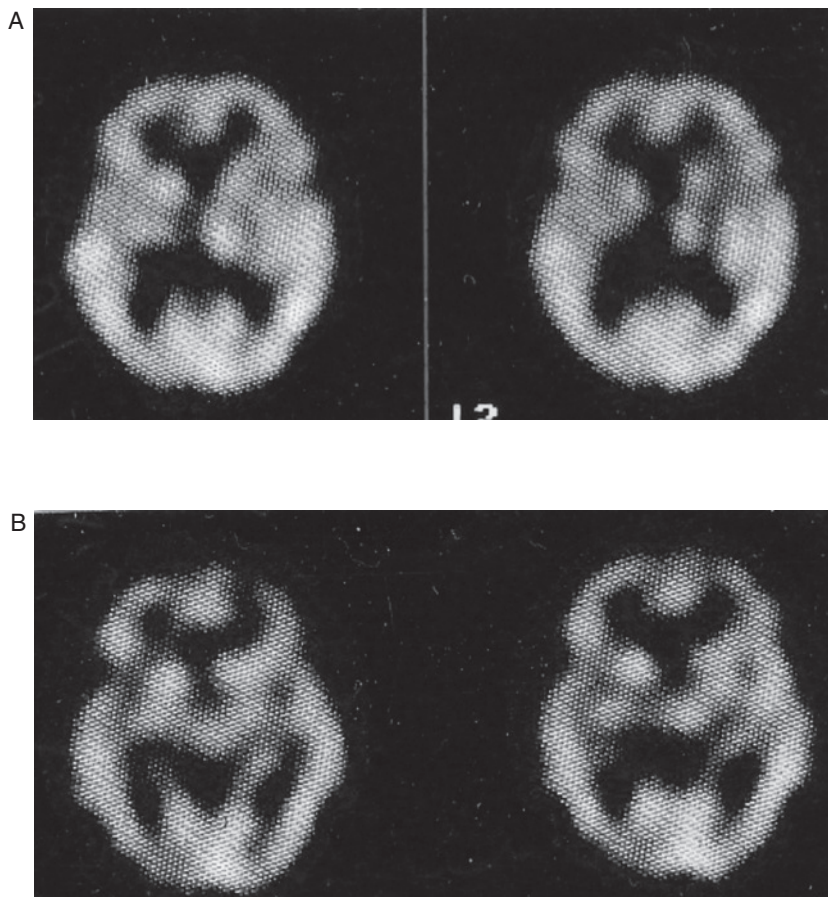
High-resolution SPECT scans showing (A) thalamic hypoperfusion in a patient with CPSP. (B) Motor cortex stimulation renormalized it, alongside analgesia. See color plate section.
